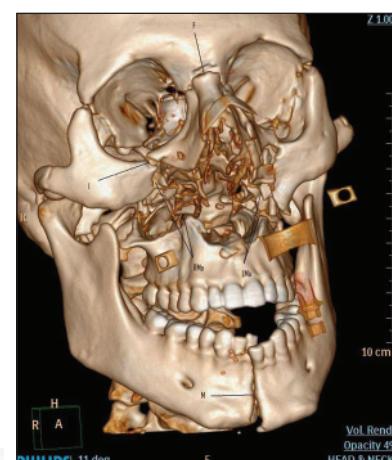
Computed tomography-scan 3 dimensional oblique view. F-Frontal fracture; I-Intra-orbital fracture; RMa-Right Maxillary fracture; LMa-Left Maxillary fracture; M-Mandibular fracture
